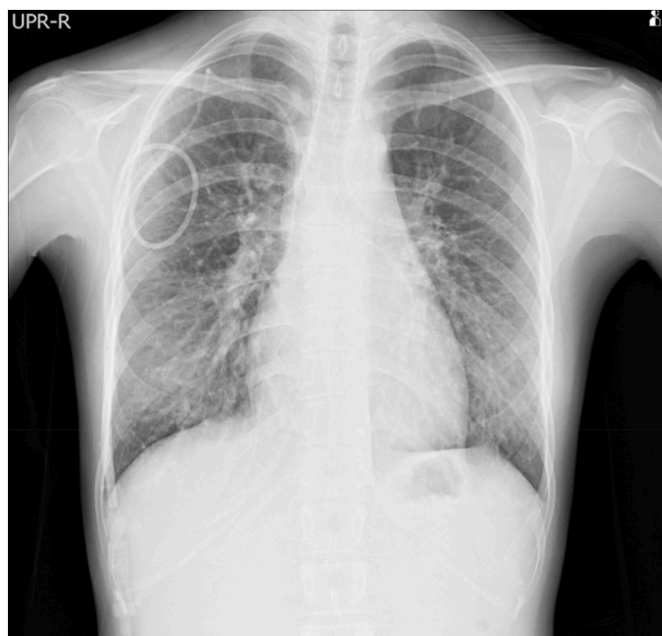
Chest radiograph shows increased cardiac ratio, dilated pulmonary arteries, and ground-glass opacities in bilateral lung fields. An extracorporeal catheter for epoprostenol infusion is inserted into the right subclavian vein.
